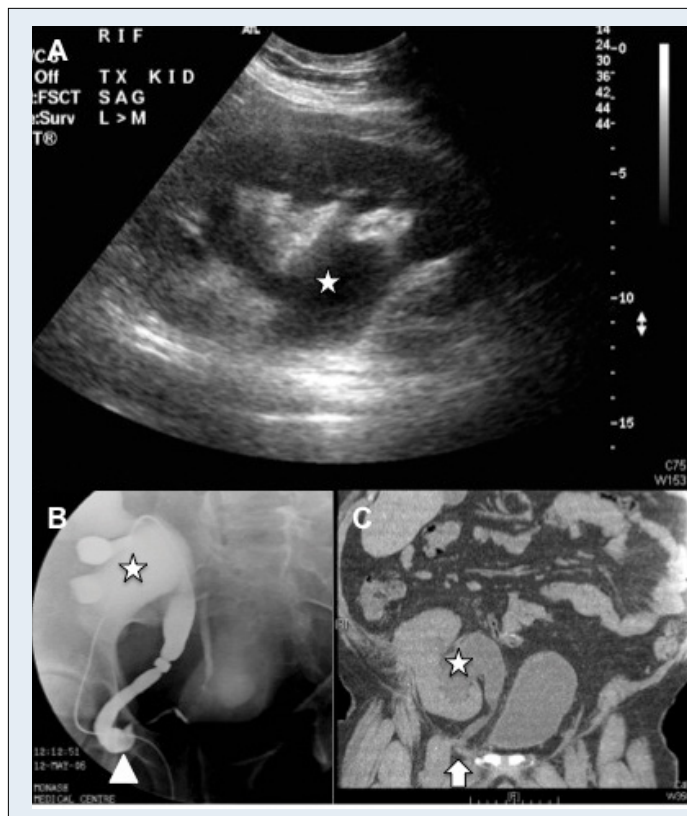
(A) B mode ultrasound showing an enlarged kidney with moderate hydronephrosis. (B) Percutaneous nephrostogram showing dilatation of the proximal half of the ureter terminating at the region of the right groin. (C) Coronal CT showing herniation of the ureter into the inguinal canal.
